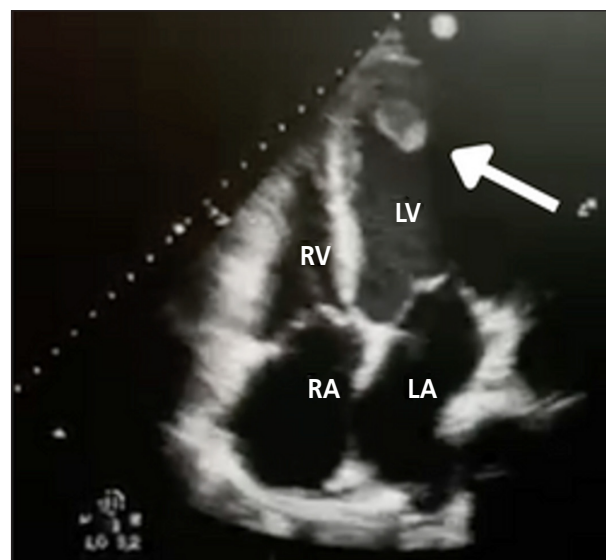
Transthoracic echocardiography (TTE) showed LV dilatation with severe systolic dysfunction markedly LV ejection fraction (EF) reduction of 28%. Abnormalities of regional wall motion were present with akinesis of anteroapical wall and hypokinesis.
